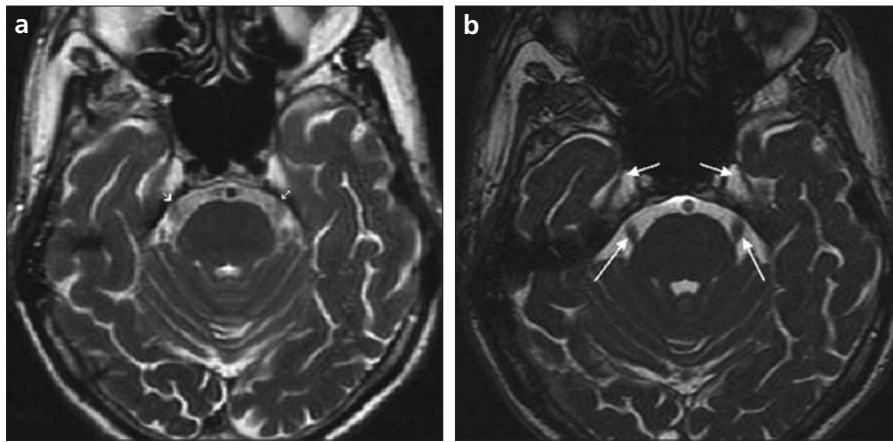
a, b. Cranial nerve V. On axial FSE T2W MR image (a) only the cisternal part of nerve V is visible (arrows). On axial 3D FIESTA MR image (b), cisternal part of nerve V (long arrows) and its branches in Meckel's cave are visible (short arrows).
